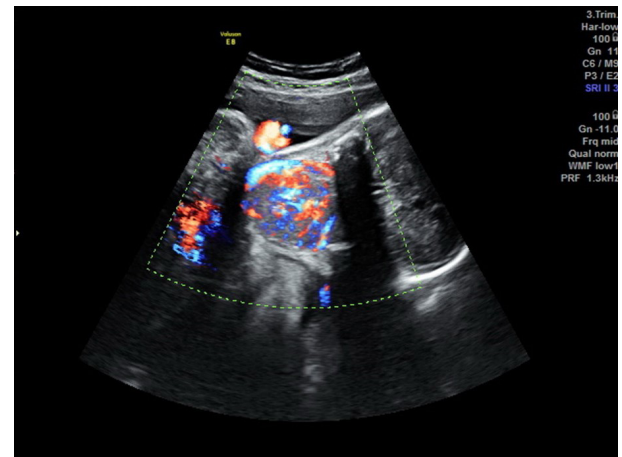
Color Doppler imaging of the fetal thyroid gland
